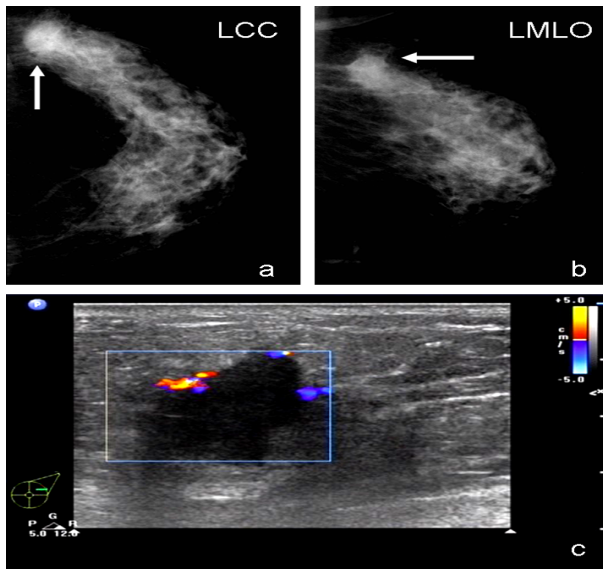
a) and b) Mammography Revealed a High Density Mass with Spiculated Border in the Outer Upper Quadrant of the Left Breast (arrows). c) In Ultrasound, the Mass Showed a Low Echoic Area with Irregular Shape and Spiculated Margin, Plunging Arteries, and Attenuating Posterior Echoes
